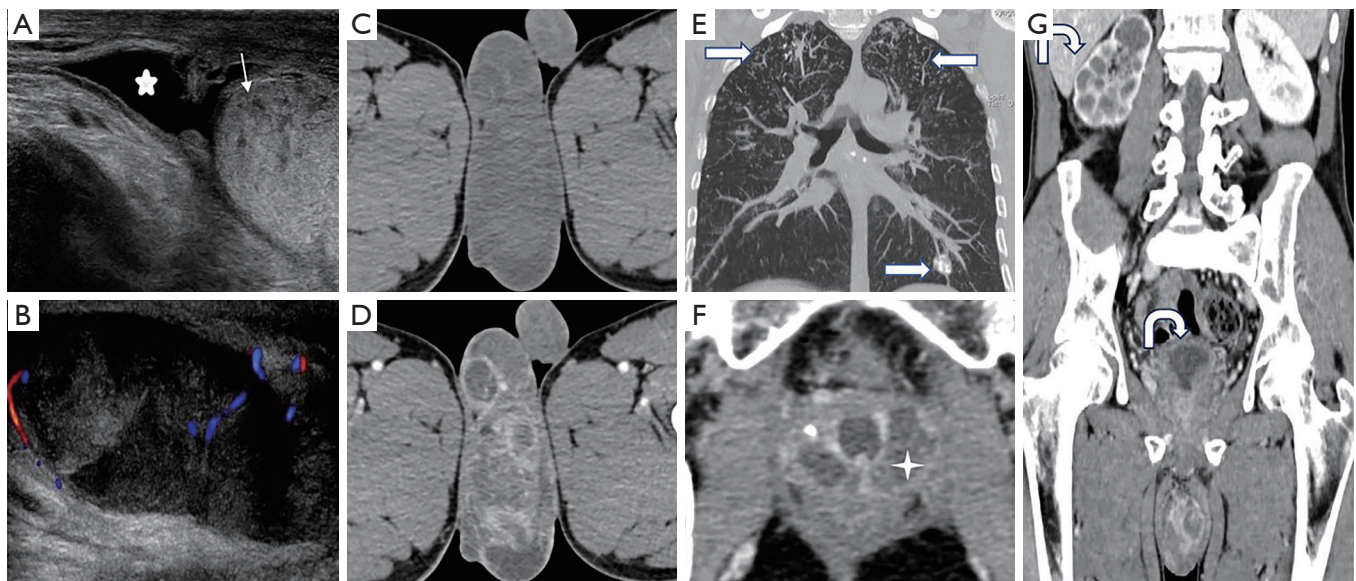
A 47-year-old Tibetan male with right-flank pain for 2 years. (A) Sonogram of right hemiscrotum showing multiple small hypoechoic nodules in the right testis (arrow), accompanied with hydrocele (star). (B) An enlarged heterogeneously hypoechoic epididymis. (C) Pelvic CT showing a heterogeneous mass with obscure boundary. (D) The septum of the lesion is significantly enhanced. (E) Lesions (arrows) distributed in bilateral upper lobes and the left lower lobe, which favors tuberculosis. (F) Lesion with similar appearance can be seen in prostate (four point star) in the scrotum can be seen in the prostate. (G) Enhanced coronal reconstructed CT image shows dilated right calyces, thickened wall of bladder (curved arrows). CT, computed tomography.
